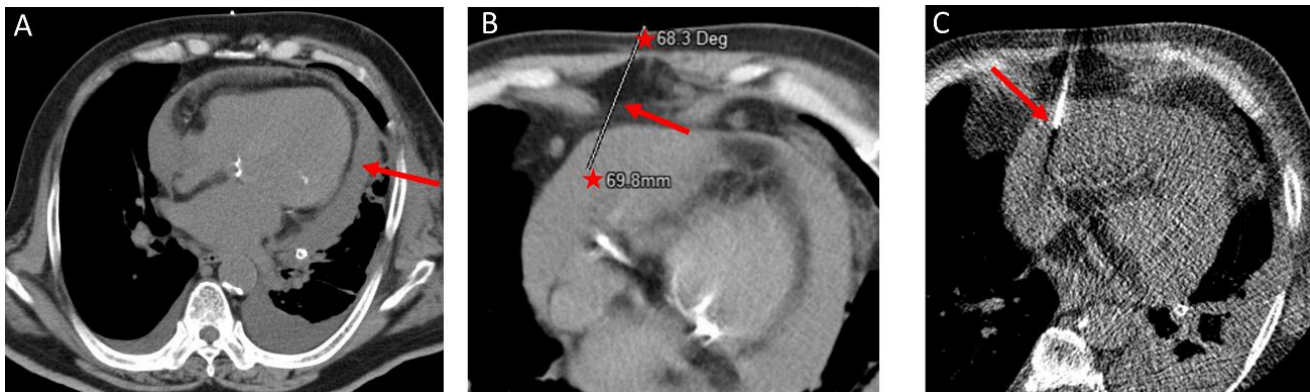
Procedural images of the computed tomography-guided approach. (A) Re-accumulation of pericardial effusion (arrow) was observed. (B) Both the distance to the pericardial cavity and angle of approach (stars) to the pericardial cavity were calculated based on the pre-designed route of needle insertion (arrow). (C) Computed tomography fluoroscopy provided accurate information about the position of the needle tip.
